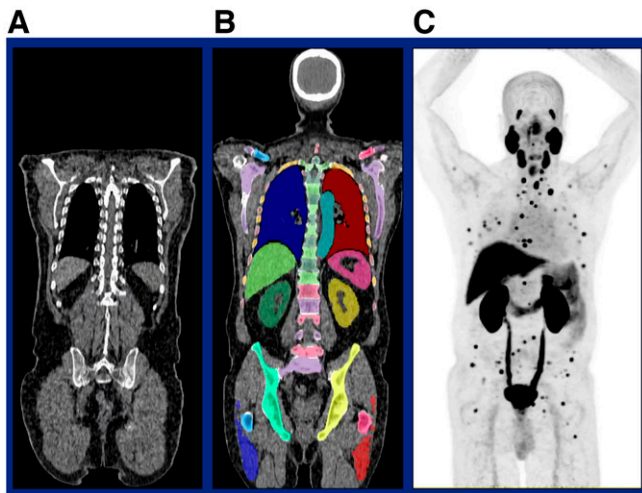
aPROMISE for rapid lesion detection and standardized quantitative evaluation for ^{18}F -DCFPyL (PSMA) imaging in prostate cancer. In this example ^{18}F -DCFPyL image (A), the aPROMISE tool performed both AI-based CT segmentation of bone and soft tissue (B) and hotspot detection/segmentation (C) to yield total PSMA SUV_{mean} , total PSMA tumor volume, and a total PSMA score. The time needed to score an ^{18}F -DCFPyL scan using aPROMISE in metastatic disease was dramatically shorter (median, 1.4 min) than average manual reading time (~15 min).
